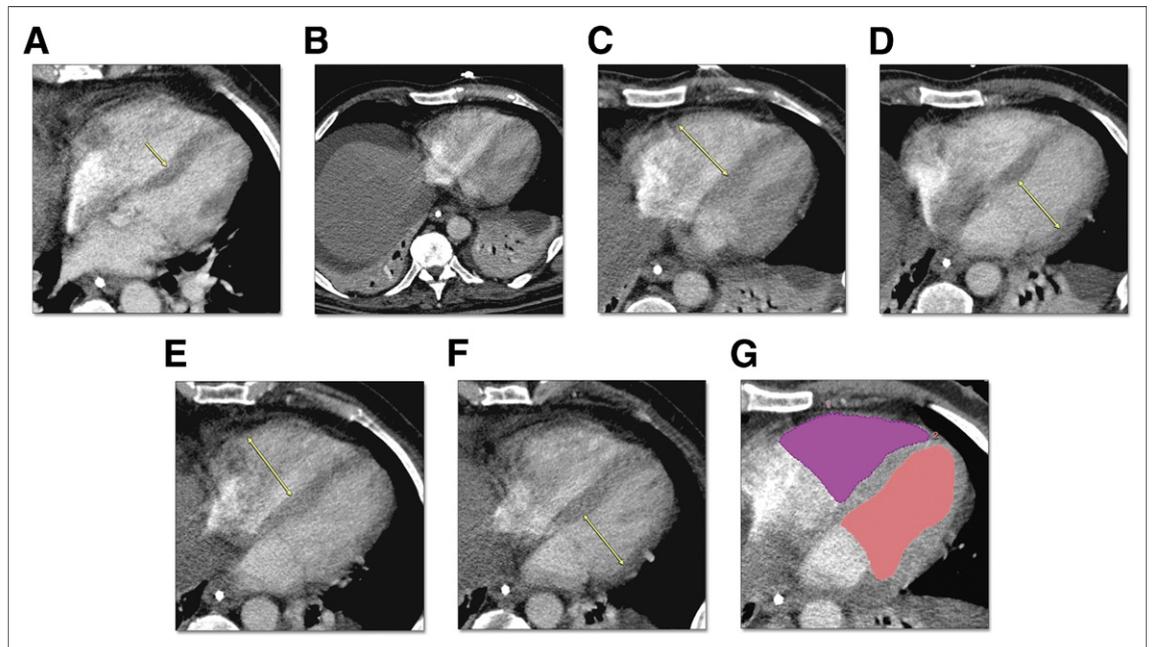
Computed Tomography Signs of RV Dysfunction in a 69-Year-Old Man
